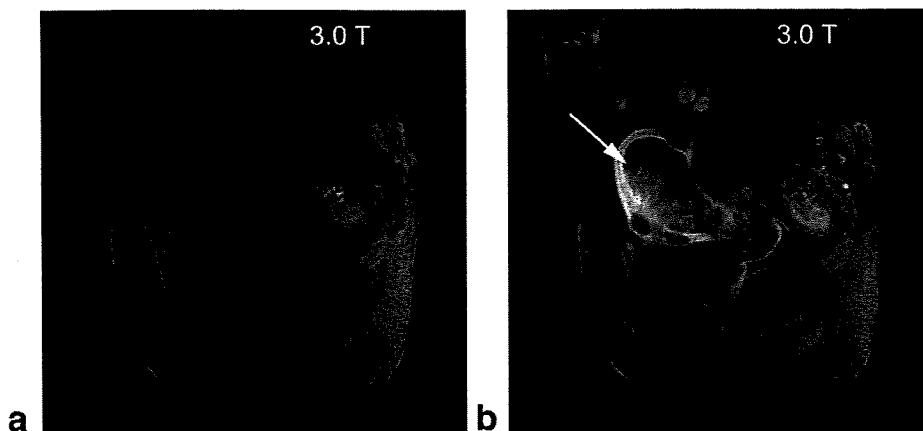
MR images of a 71-year-old woman with endometrial carcinoma (endometrioid adenocarcinoma, grade 3, arrow). T1-weighted 3D gradient echo images (4.6/2.3, 12°) at 3.0 T in the parasagittal plane obtained (a) before and (b) 70 seconds after contrast injection show excellent contrast enhancement but slightly inferior image homogeneity compared to those at 1.5 T (see Fig. 2).
